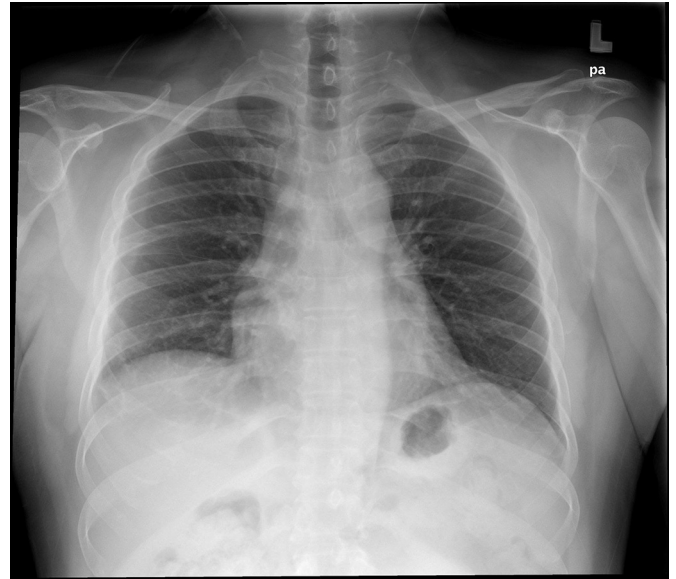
Erect chest radiograph of the patient on initial presentation. Air-space heterogeneous opacities noted over the right lower zone accompany by a pleural effusion.
